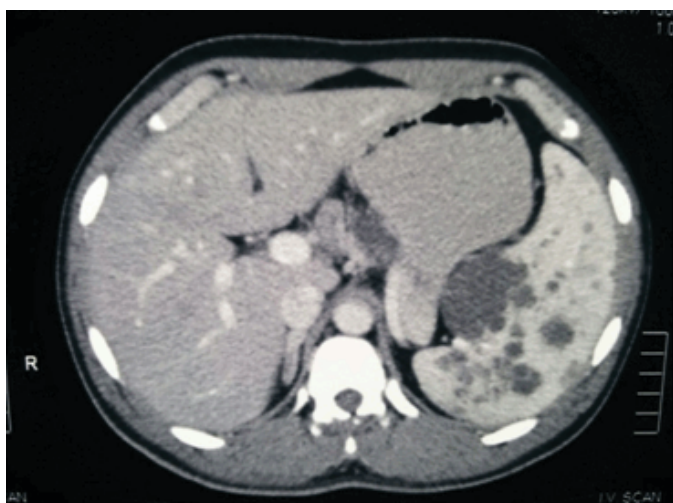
CT Image showing cystic lesions in spleen.
